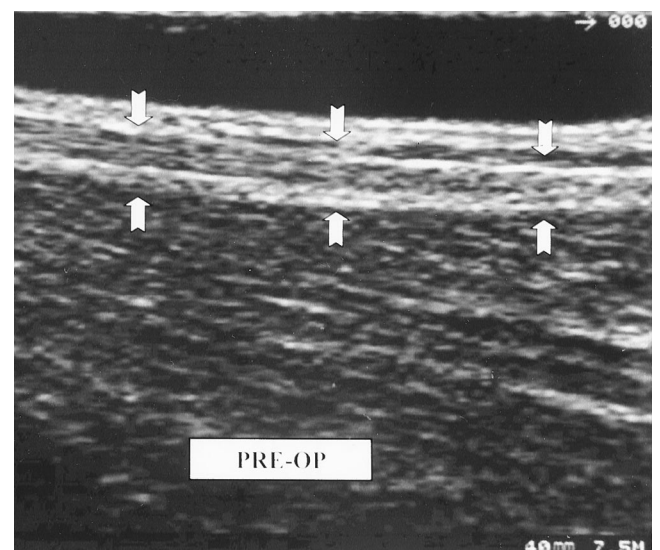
Longitudinal sonogram of a normal semitendinosus tendon (outlined by arrows).
